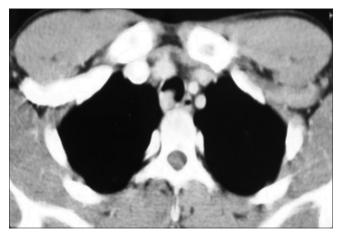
Computed tomography chest showing a mass in the upper trachea arising from the right postero-lateral wall
